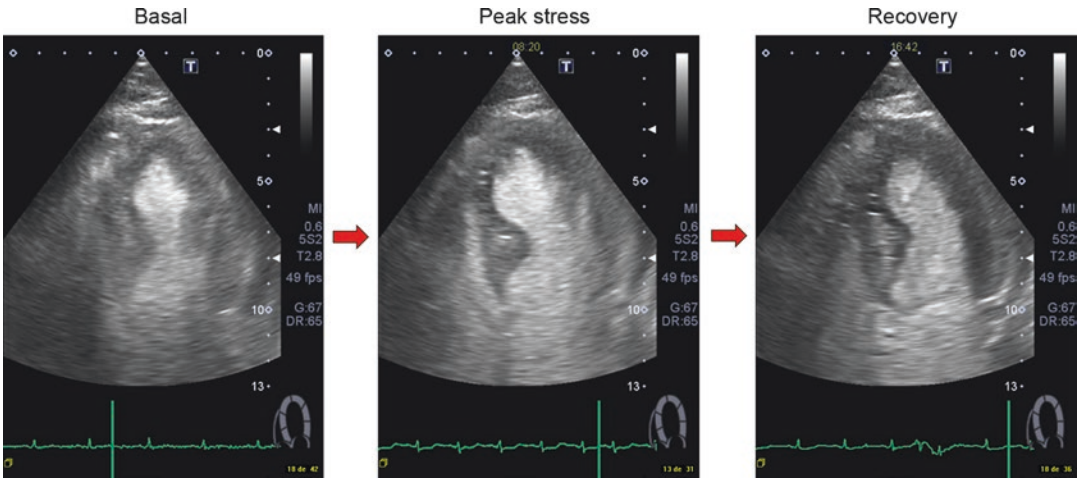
This figure shows a contrast-enhanced echo stress in a survival patient with history of Hodgkin's lymphoma treated with chemo-/radiotherapy that refers new-onset exertional dyspnoea. Contrast-enhanced stress echo allows to better detect endocardial border and, consequently, wall motion abnormalities. Left panel: after contrast injection apical four chamber view at rest. Central
